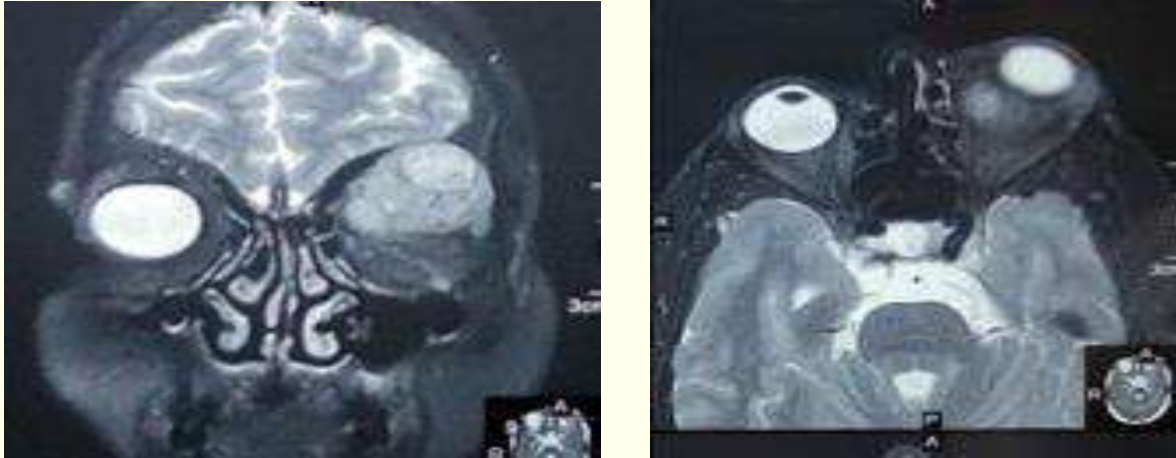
Recent MRI scans showing extraconal intra-orbital enhancing rounded soft tissue lesion in the superior compartment of the left orbit
